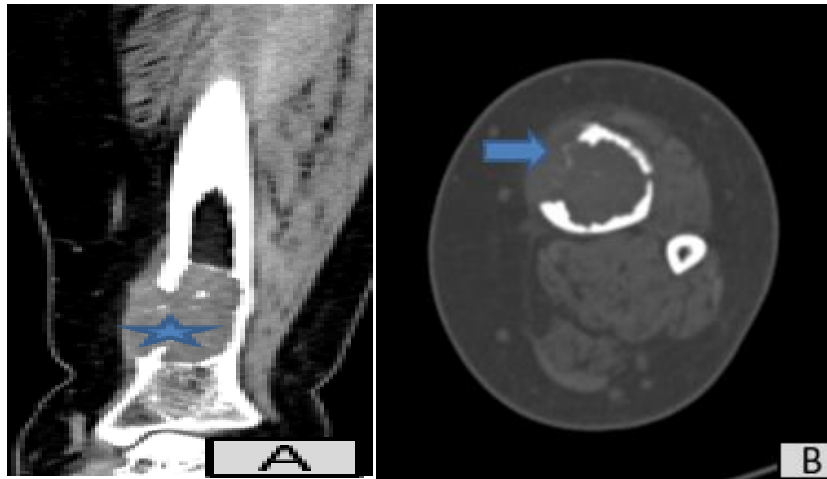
CT scan of the left leg centered on the lesion: axial in bone window (A), reconstruction sagittal in soft tissue window in post contrast product (B): unifocal lesion located at the distal third of the diaphysis of tibia with cortical disruption (arrow), involvement of the medullary canal and surrounding soft tissue extension (asterisk) with enhancement after injection of the product contrast
